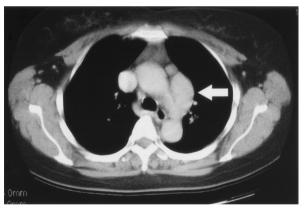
CT scan of the chest showed a homogeneous and wellenhanced solitary tumor lateral to the aortopulmonary window (*arrow*).
